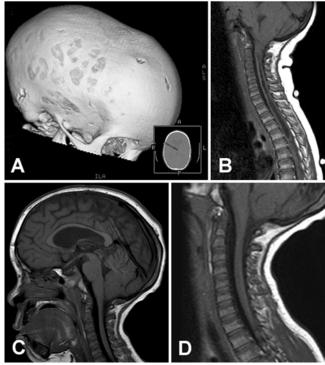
Imaging studies obtained in a 3-year-old boy presenting with scaphocephaly. A: Reconstructed CT scan demonstrating fusion of the sagittal suture, coronal suture, and lambdoid sutures bilaterally, as well as lückenschädel of the skull. Inset: Two-dimensional depiction of the "viewing angle" that is depicted in the larger 3D image. B: Sagittal MR image showing cerebellar tonsillar descent with crowding at foramen magnum. The patient underwent cranial vault expansion and remodeling including frontoorbital advancement. No CM decompression was performed. C: Three years postoperatively, tonsillar descent has improved and there is less crowding at foramen magnum. D: The spinal syrinx has resolved.
